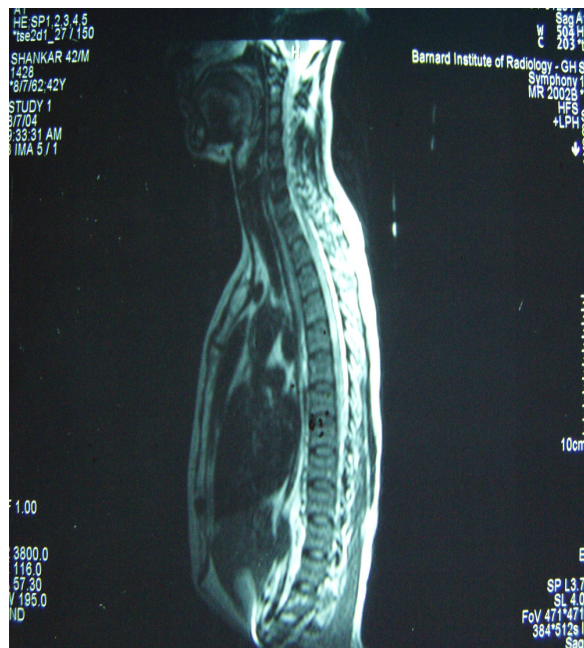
T2 weighted saggital MRI of the thoracic spine showing diffuse ill-defined hyper intensities involving mid and lower dorsal spine
